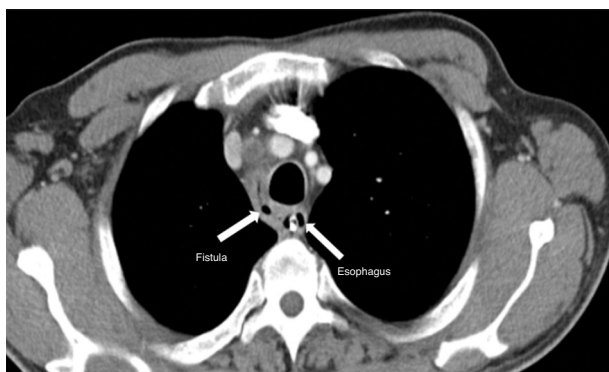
Thoracic CT scan revealing an esophagomediastinal fistula.
